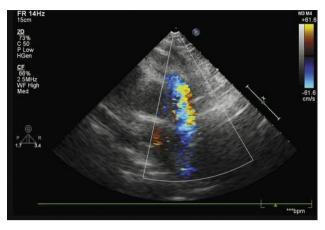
Echocardiography revealed tricuspid regurgitation, pulmonary hypertension, left ventricular diastolic dysfunction and pericardial effusion.
